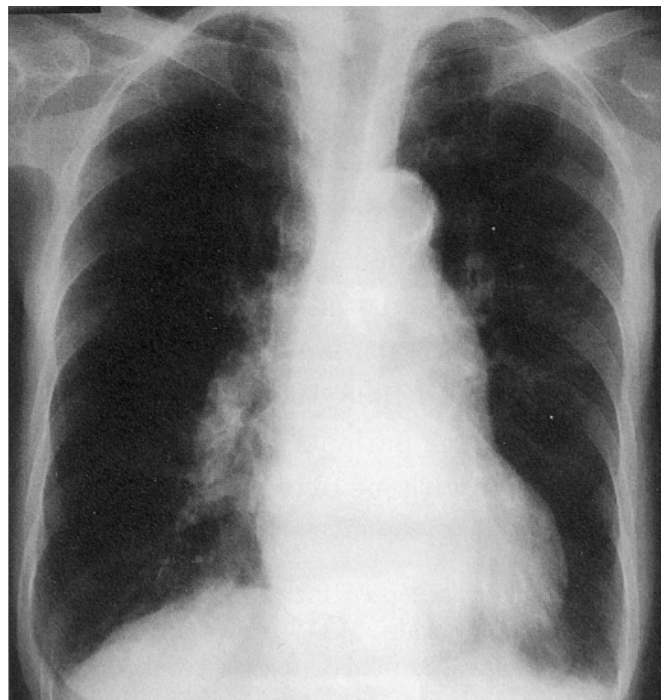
Chest radiograph showing dilated pulmonary arteries, but no infiltration in the lung fields.
